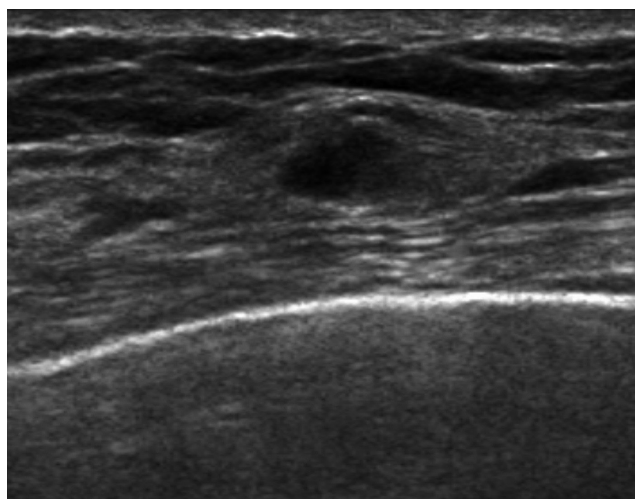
A supplementary screening US detected cancer case in a 40-year-old woman that was initially assessed as BI-RADS category 3 (case 8 in Table 2). Initial supplementary screening US was assessed as BI-RADS 3 due to multiple small oval isoechoic nodules in both breasts. Diagnostic US after 6 months revealed that the mass in right breast increased in size up to 1.1 cm, and it was still not palpable. Both initial and follow-up mammograms were negative (not shown here). The pathologic diagnosis was invasive ductal cancer. US, ultrasound; BI-RADS, Breast Imaging Reporting and Data System.
